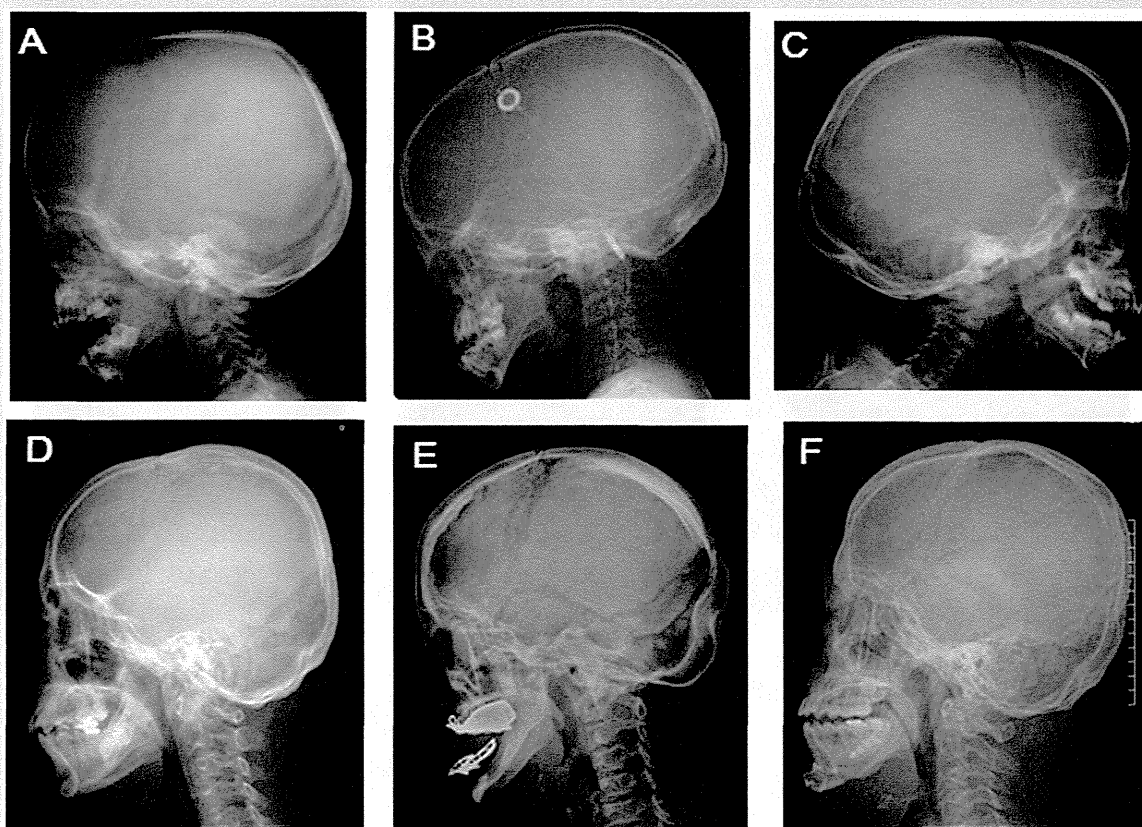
Lateral skull radiographs. All patients showed Wormian bones. A: Patient 1 at 2 years and 11 months of age. B: Patient 2 at 13 years of age. C: Patient 3 at 2 years of age. D: Patient 4 at 31 years of age. E: Patient 5 at 41 years of age. F: Patient 6 at 20 years of age.
